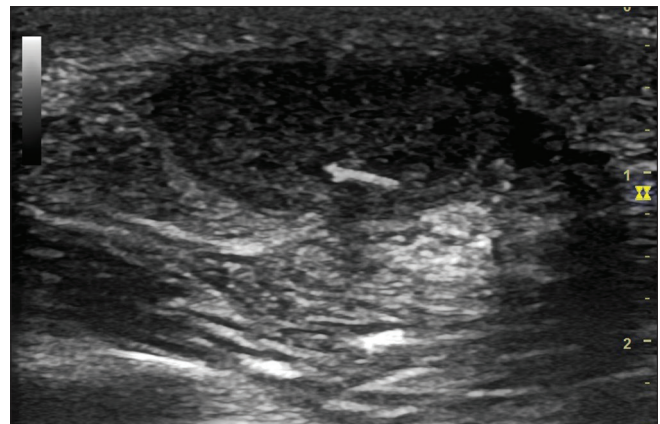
Point-of-care sonogram showing a heterogeneous hypoechoic mass (buccal space abscess) with a linear echogenicity (foreign body)
